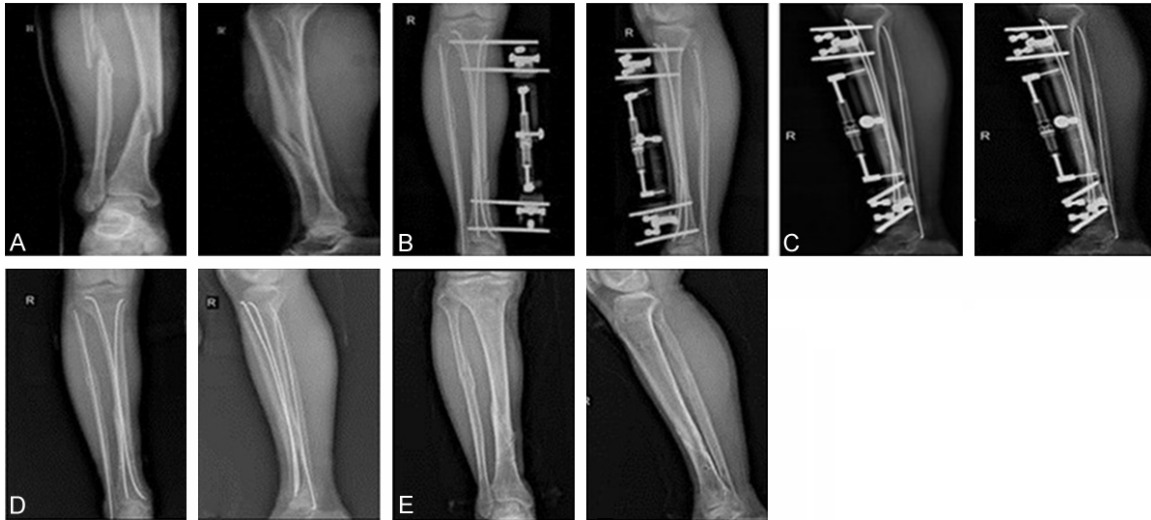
Male patient, 49 years old. A. Anteroposterior and lateral X-rays of the tibia-fibula fracture. B. Anteroposterior and lateral X-rays after tibial intramedullary elastic nail + external fixation, as well as fibular intramedullary elastic nail fixation. C. Anteroposterior and lateral X-rays 6 months after surgery showing bony union of the tibia. D. Anteroposterior and lateral X-rays after removal of external fixator, 6 months after surgery. E. Anteroposterior and lateral X-rays after removal of internal fixations, 7 months after surgery.
